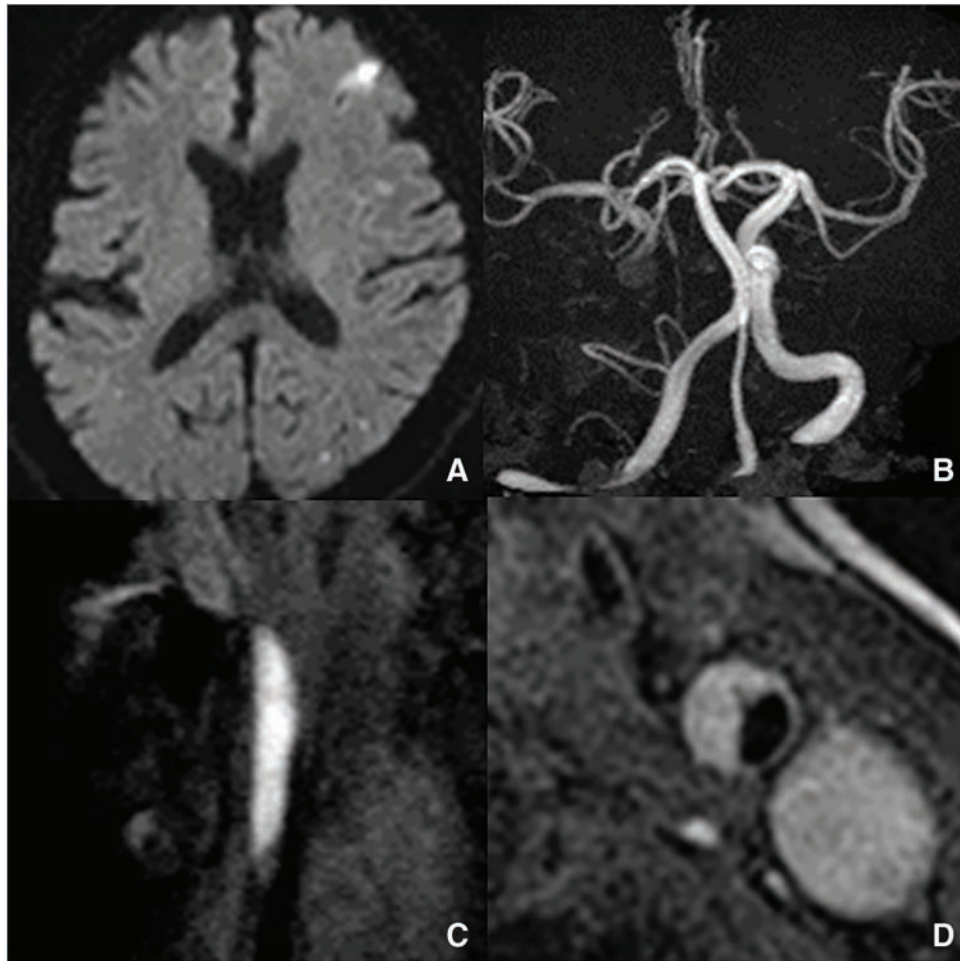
(A) Diffusion-weighted imaging of the head shows cerebral infarction in the territory of the left middle cerebral artery. (B) MRA of the head reveals no findings suggestive of occlusion or stenosis of the right large vessels, except for the absence of the chronically occluded right internal carotid artery. (C) Magnetization-prepared rapid gradient-echo imaging shows a high-intensity signal of the CCA. (D) T1-weighted black-blood imaging demonstrates a high-intensity signal of the CCA, suggesting vulnerable plaque. CCA: common carotid artery
